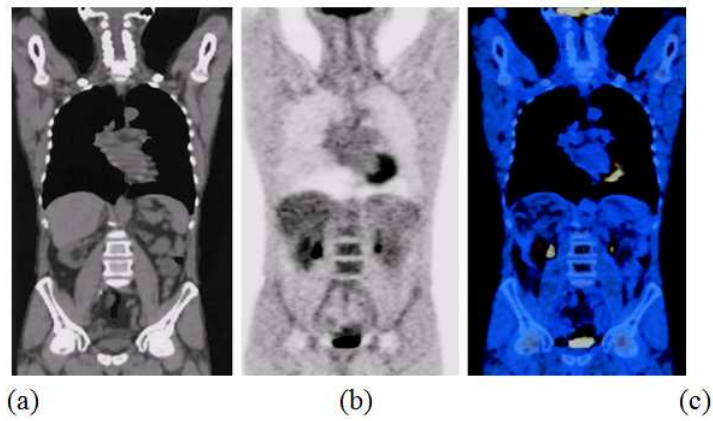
Coronal CT (a), PET (b), and PET-CT registered (c) images
